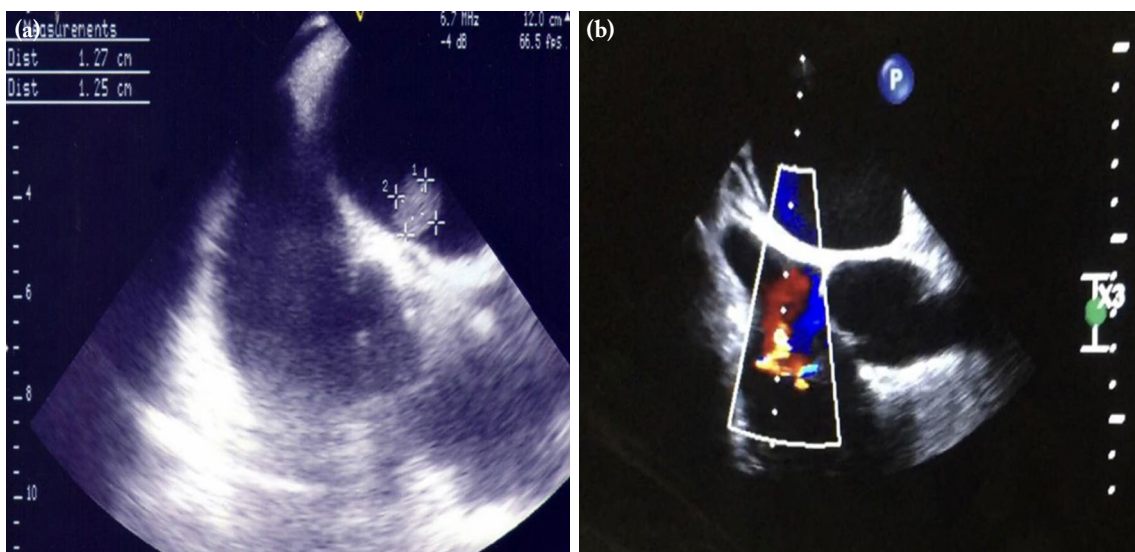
(a) Transthoracic echocardiogram showing vegetation in the subaortic region in a male patient who has a rheumatic valvular disease. (b) There is an aortic valvular insufficiency.
